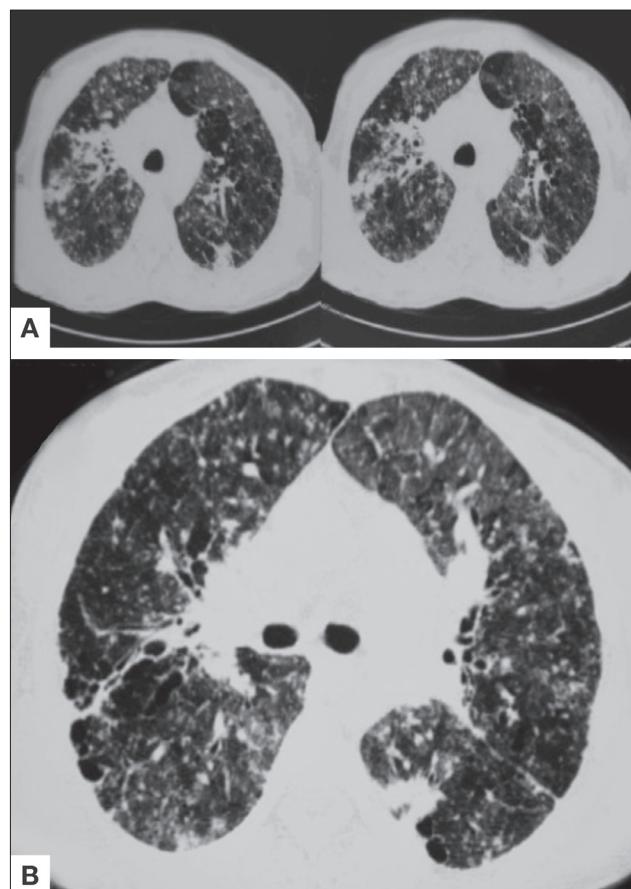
(Case 1) (A) Presenting HRCT, (B) presenting HRCT.
